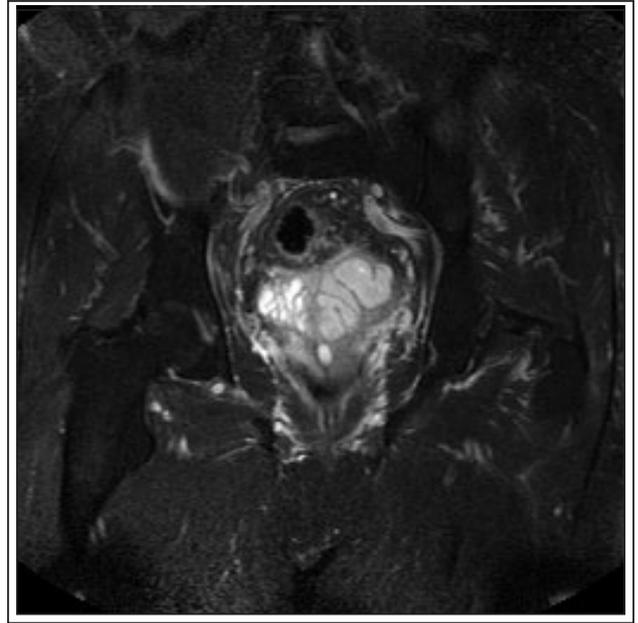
Coronal magnetic resonance imaging of the pelvis, T2 phase. Enlarged left seminal vesicle with multiseptated 5.1 cm x 3.3 cm x 4.6 cm fluid collection.
